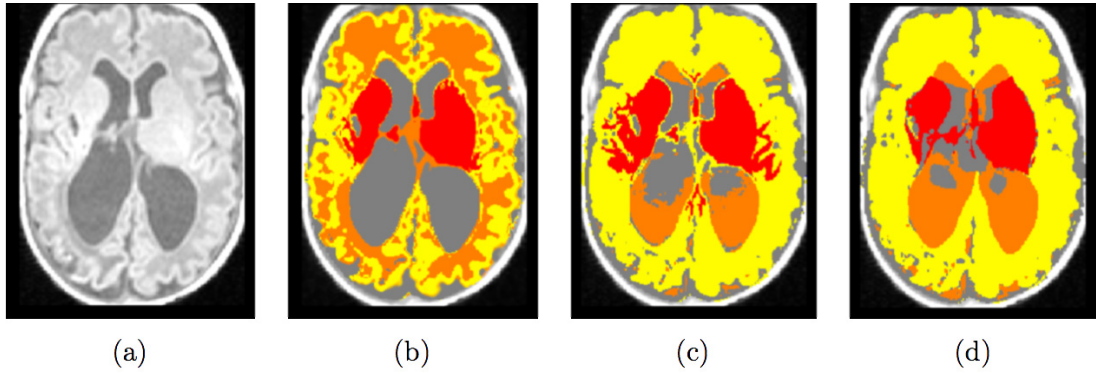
Example (case D in section 3.2.3) of (a) original T1-weighted image and (b) the proposed AdaPT segmentation, followed by (c) the proposed segmentation with prior relaxation but without the priors over the model parameters (section 3.2.2) and (d) the proposed segmentation with priors over the model parameters but without the anatomical prior relaxation (section 3.2.2). The algorithm does not converge to a realistic solution without both improvements. The yellow, red, orange and grey labels represent the cortical and sub-cortical GM, WM and CSF spaces respectively.
